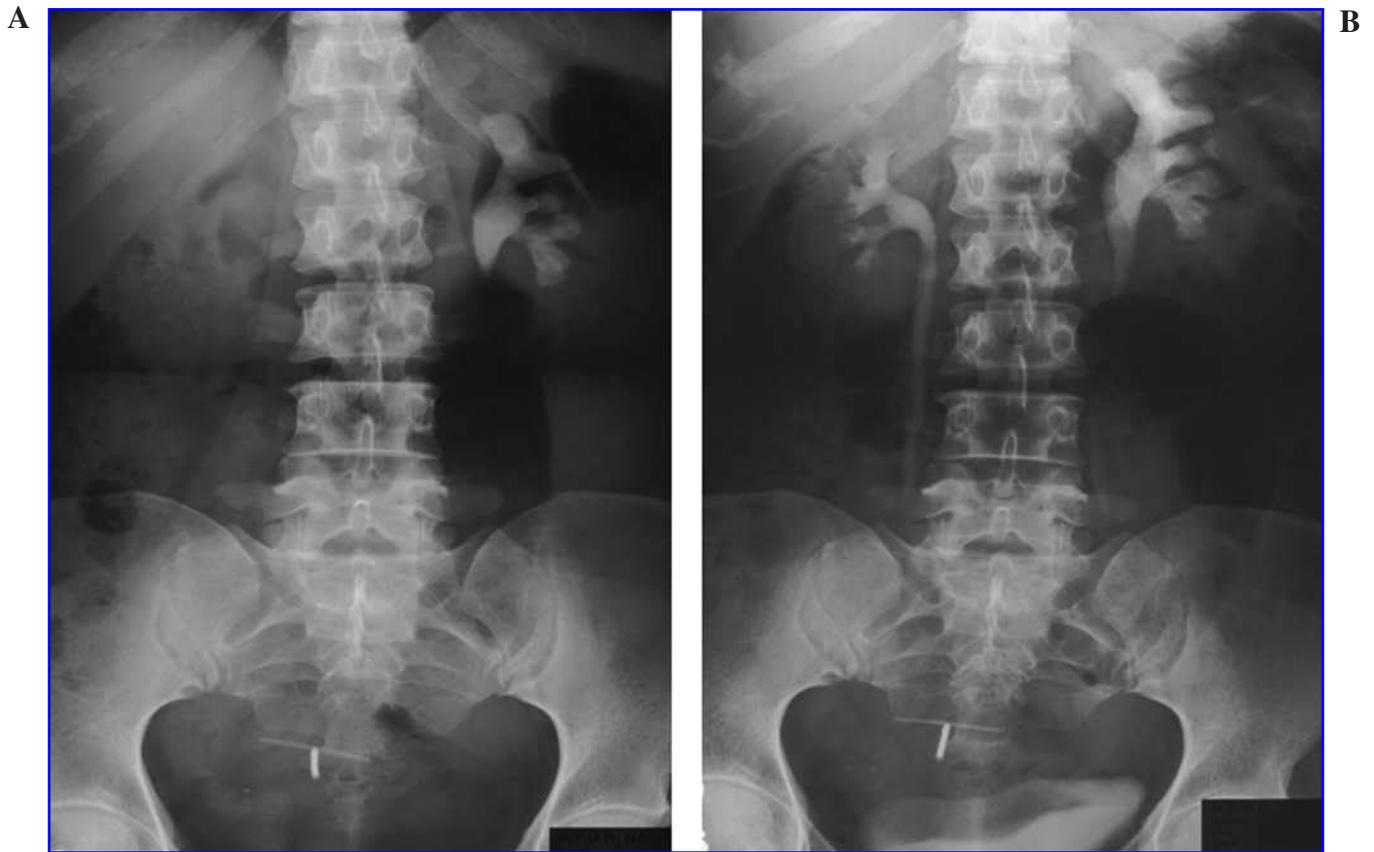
Left complete staghorn. (A) KUB x-ray. (B) IV urogram.
